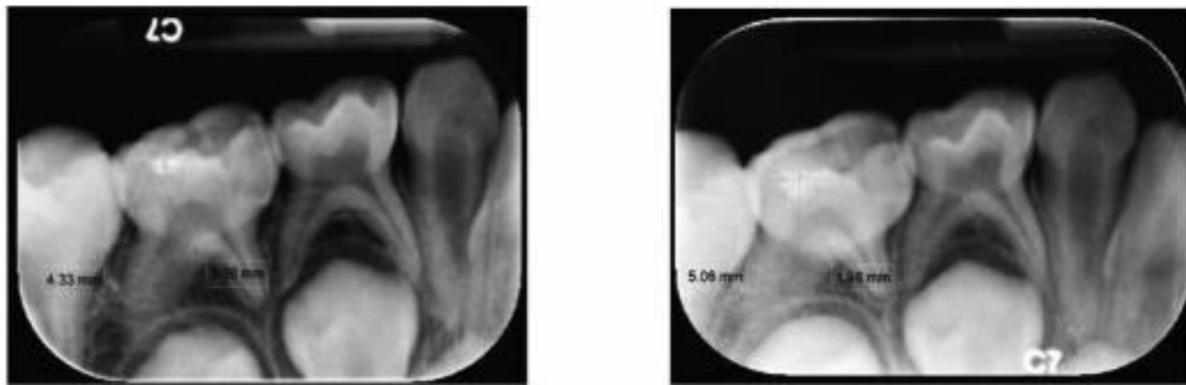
Radiographs showing pre-operative (left) and post-operative (right) measurements of cavity width and depth in tooth # 85.
